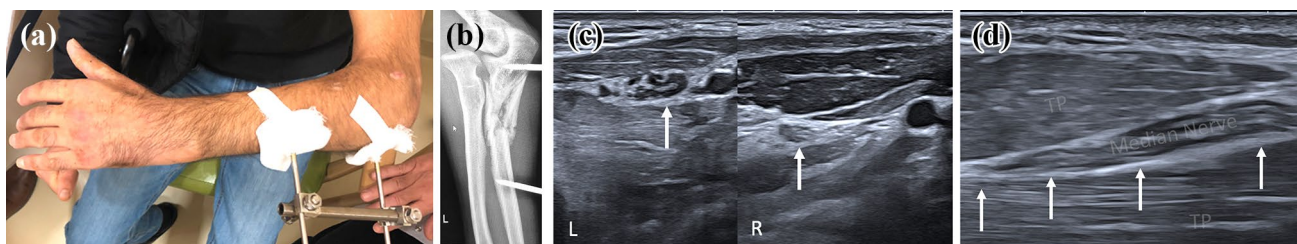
Shrapnel lesion of the left elbow and forearm (patient #7). Paresis in the territory of the median nerve. Neurapraxia in electroneuromyography. A The wounded limb. B Ulna fracture treated by external fixator. C Comparative axial ultrasound sections showing
